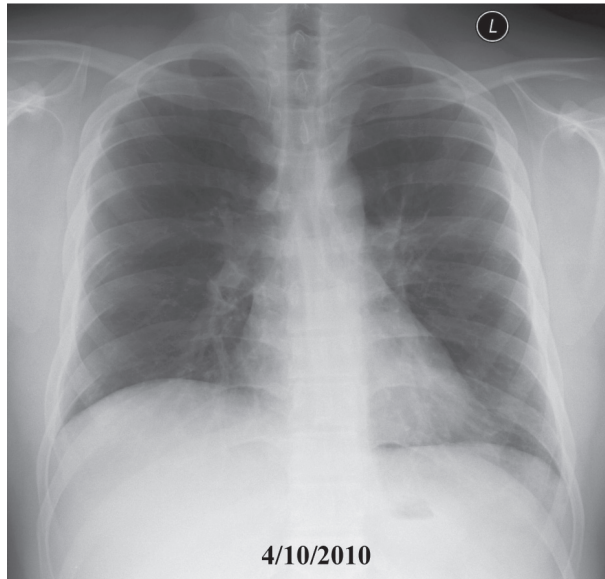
After Treatment about 1 month; Chest x-ray shows completely clear.
